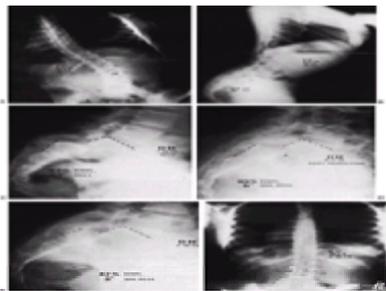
A patient was seen at the age of 12 years 3 months with a “spasm” scoliosis, lumbosacral pain, and sciatica. B: The lateral standing radiograph showed a relatively vertical sacrum, 67% displacement, a 26-degree slip angle, and total lordosis from T1 to L5. Note how the torso is displaced forward in relation to the pelvis. C: The spot lateral lumbosacral view shows an elongated pars of L5, with a pars defect near the pedicle. D: The patient was treated by nerve root decompression, L4-S1 transverse process fusion, and partial reduction by double pantaloons cast application in a hyperextended position. The percentage of slip was reduced from 67 to 53%, but, more importantly, the slip angle was reduced from 23 to 6 degrees. The patient was nonambulatory for 3 months, then was ambulatory in a body cast for an additional 3 months. E: At a 2-year follow-up visit the patient's fusion was solid, she was free of pain, and there was no loss of correction. F: An anteroposterior view 3 years after surgery shows the solid lumbosacral fusion and total disappearance of the scoliosis.
